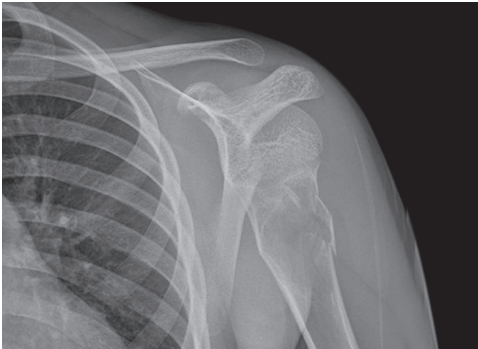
X-ray: Pathological fracture
